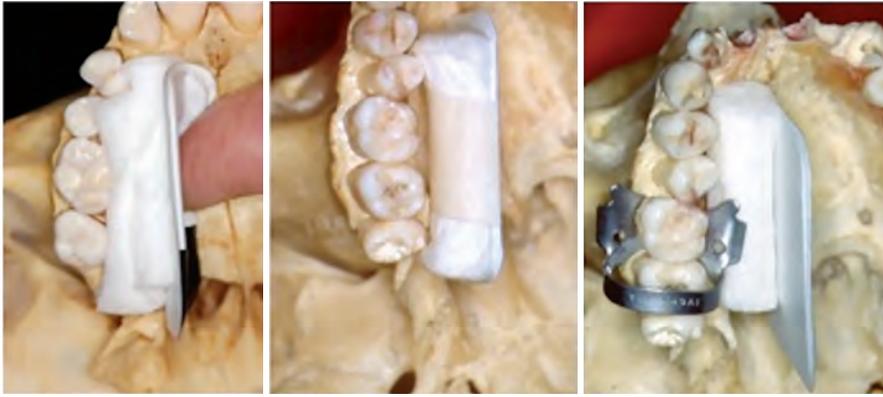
Different ways to obtain parallelism between the tooth and the radiographic film with the aid of a cotton roll and a rubber dam clamp, using Le Master's technique.
